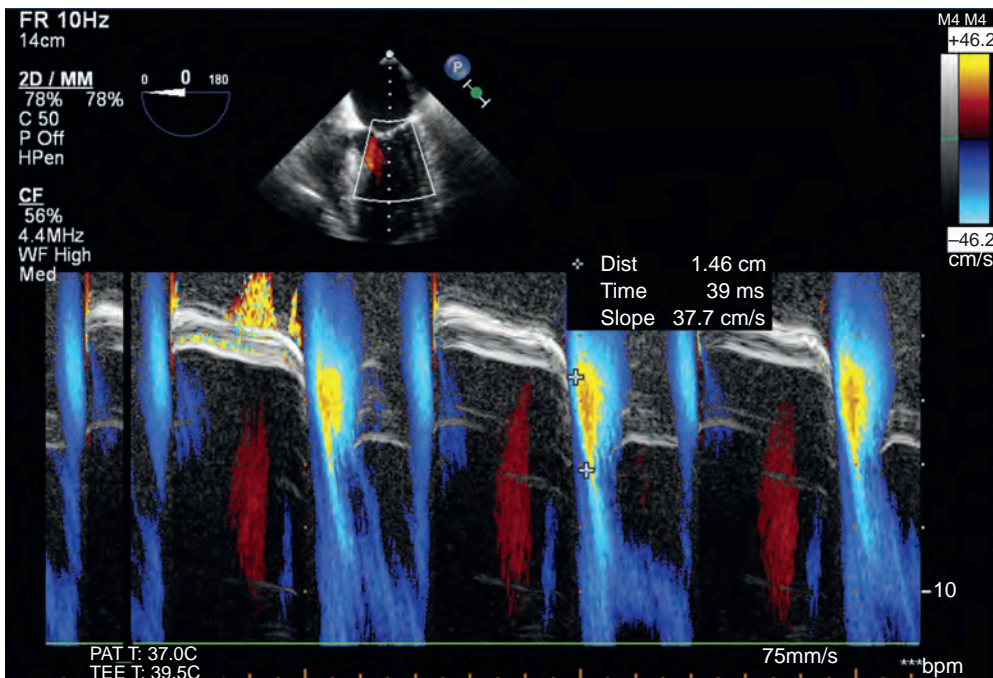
Determination of color M-mode mitral valve blood flow propagation velocity (V_p). A color Doppler M-mode envelope is obtained by placing the M-mode scan line into the center of left ventricular (LV) inflow aligned from base to apex. V_p is determined as the slope of the first aliasing velocity. A value of V_p less than 45 cm/s suggests that early LV filling is attenuated, consistent with LV diastolic dysfunction.
